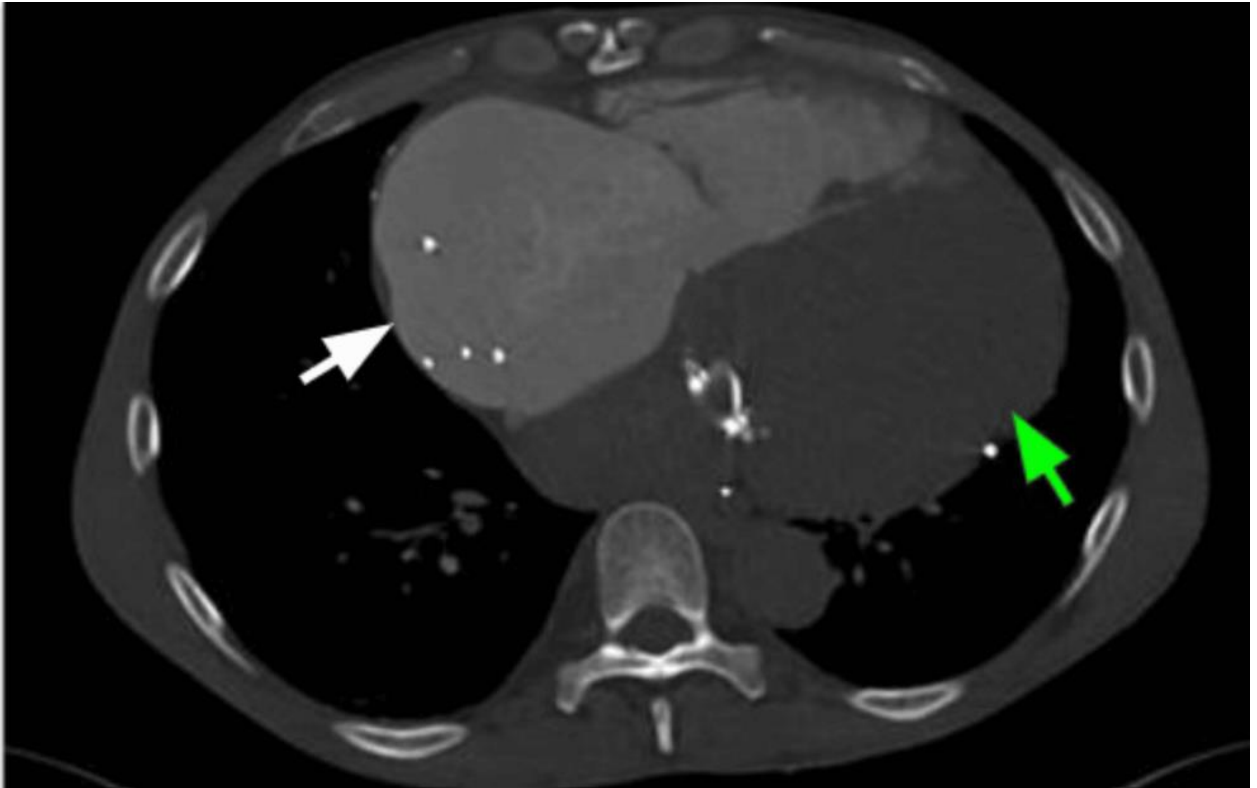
Computed Tomography Chest with Pulmonary Angiography demonstrating severe cardiomegaly, especially in the right atrium (white arrow) and left ventricle (green arrow)
